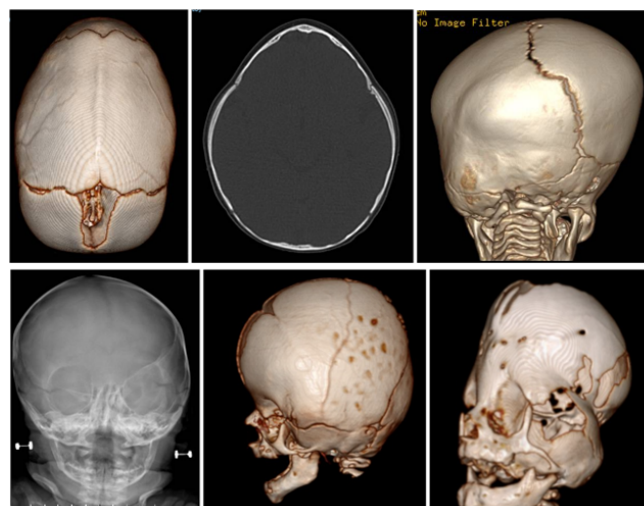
From left to right. CT showing absence of sagittal suture and dolichocephalic skull configuration. Axial CT of patients with trigonocephaly. Posterior CT view with evidence of premature closure of left parieto-occipital suture. Plain radiograph of anterior plagiocephaly. Brachycephaly in patients with Crouzon's Syndrome. CT of patients with oxycephaly and multiple closed sutures.
